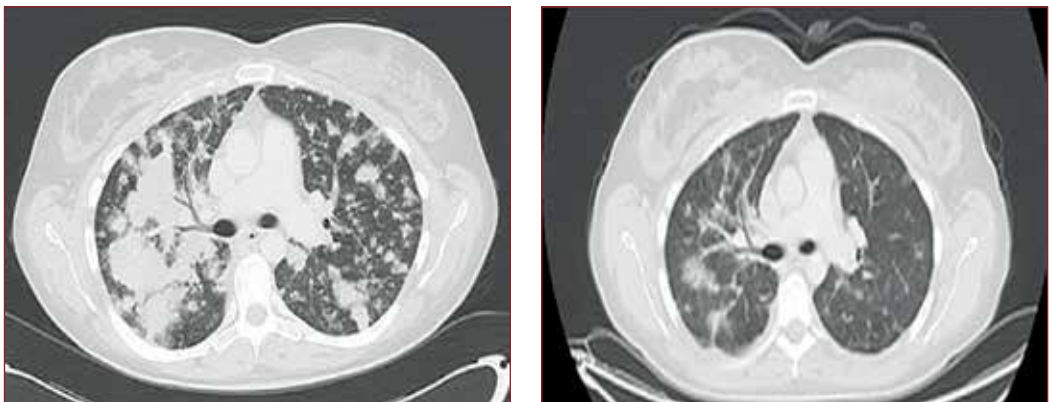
Left: Patient with stage IVA ALK-fusion positive NSCLC treated with crizotinib. Right: Interval CT scan after 2 months of crizotinib shows partial response.
